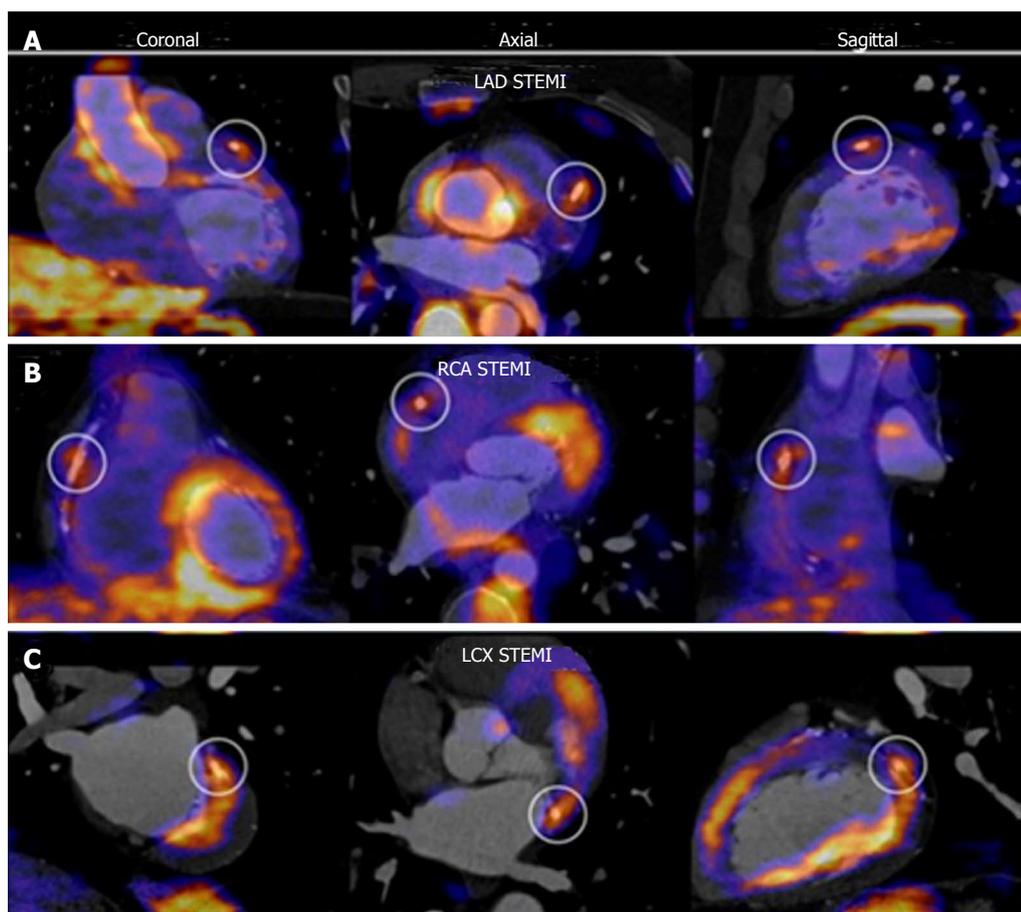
Fluorodeoxyglucose positron emission tomography of the coronary arteries. PET CT fusion imaging in three cases of patients with STEMI. An increased ^{18}F -FDG uptake at stent site is shown in different culprit vessels, from A to C: LAD, RCA and LCX. Adapted with permission from Cheng *et al*^[107]. This research was originally published in JNM. ©by the Society of Nuclear Medicine and Molecular Imaging, Inc. FDG: Fluorodeoxyglucose; PET: Positron emission tomography; STEMI: ST elevation myocardial infarction; LAD: Left anterior descending coronary artery; RCA: Right coronary artery; LCX: Left circumflex coronary artery.
